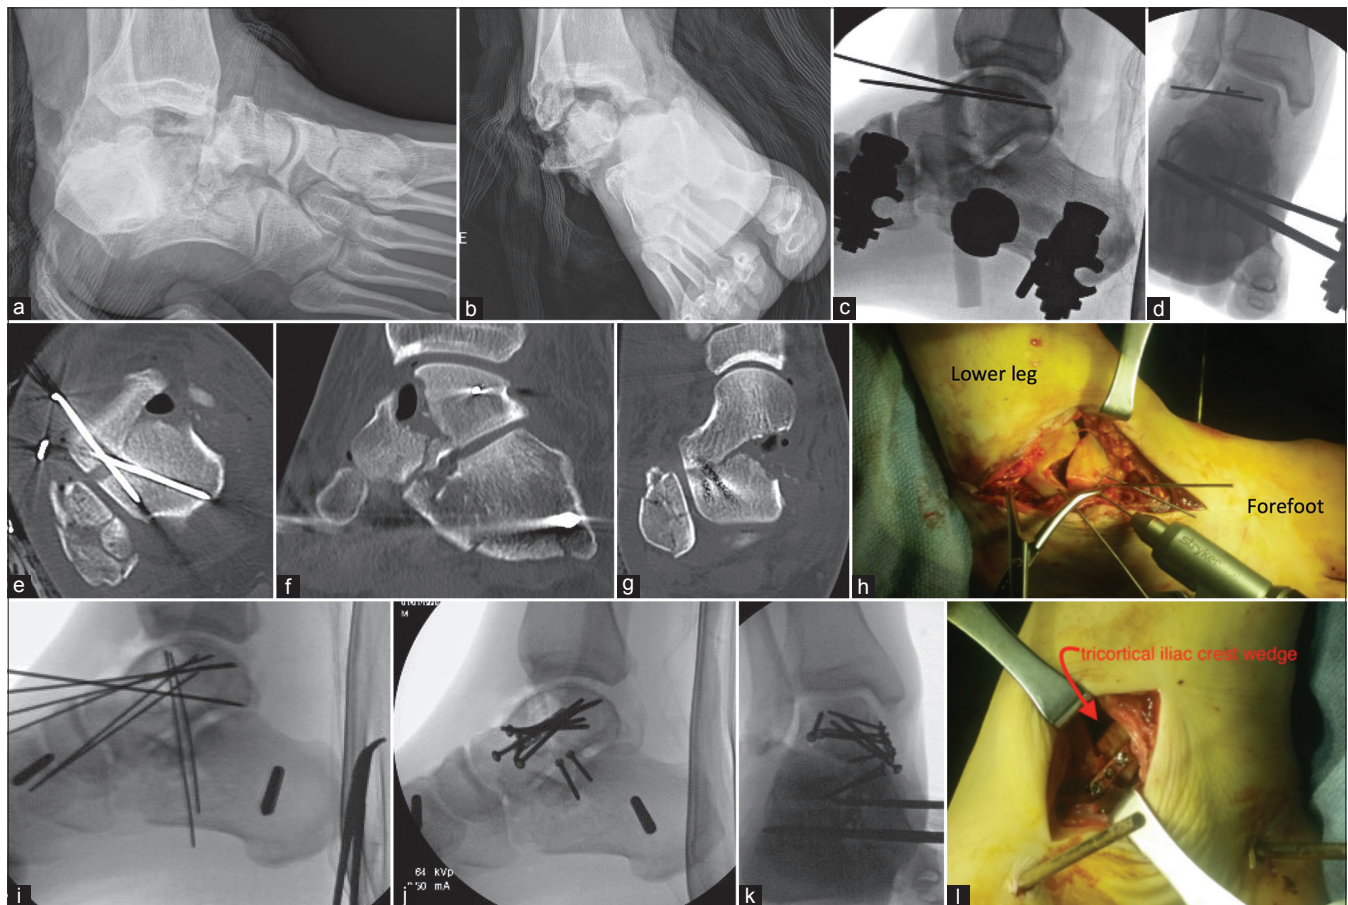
(a and b) Lateral and mortise views radiographs of ankle joint showing a severe fracture dislocation as a result of a motor vehicle collision. (c and d) Fluoroscopic views of ankle showing the fracture was open and was treated with emergent debridement, reduction, and provisional stabilization with K-wires and an external fixator. (e-h) Computed tomography scans and surgical image demonstrating traumatic loss of bone at the time of the open injury. (i-k) Intraoperative fluoroscopic views of ankle showing films demonstrating the reduction including provisional fixation with K-wires, as well as a final fixation with plates and screws. (l) The patient had a significant amount of bone loss along the medial neck, so a tri-cortical iliac crest wedge was used to fill the void and held in place with a mini fragment plate and screws
